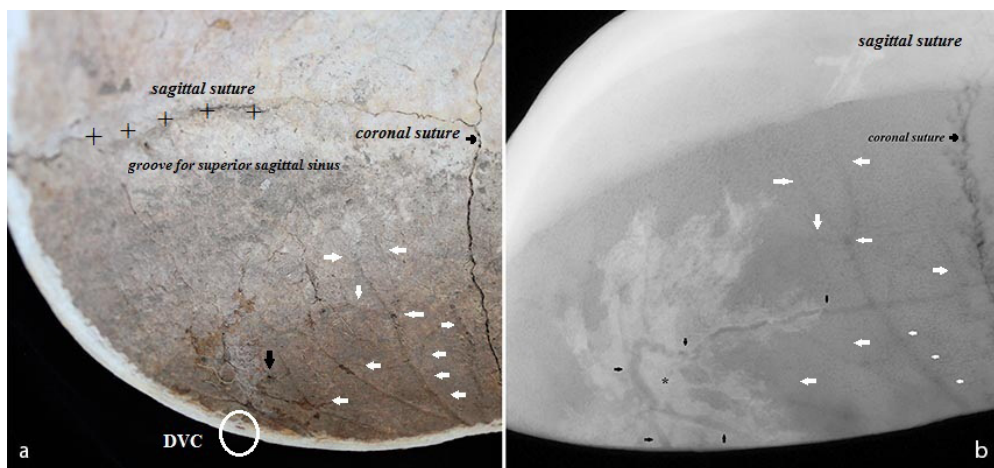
A sectioned calvaria: a) an image of the internal aspect; b) a radiograph after injection with a radiocontrast agent. Indications: diploic venous channels (DVCs, black arrows); grooves for middle meningeal vessels (white arrows); radiocontrast agent (asterisk); groove for superior sagittal sinus (plus signs)
